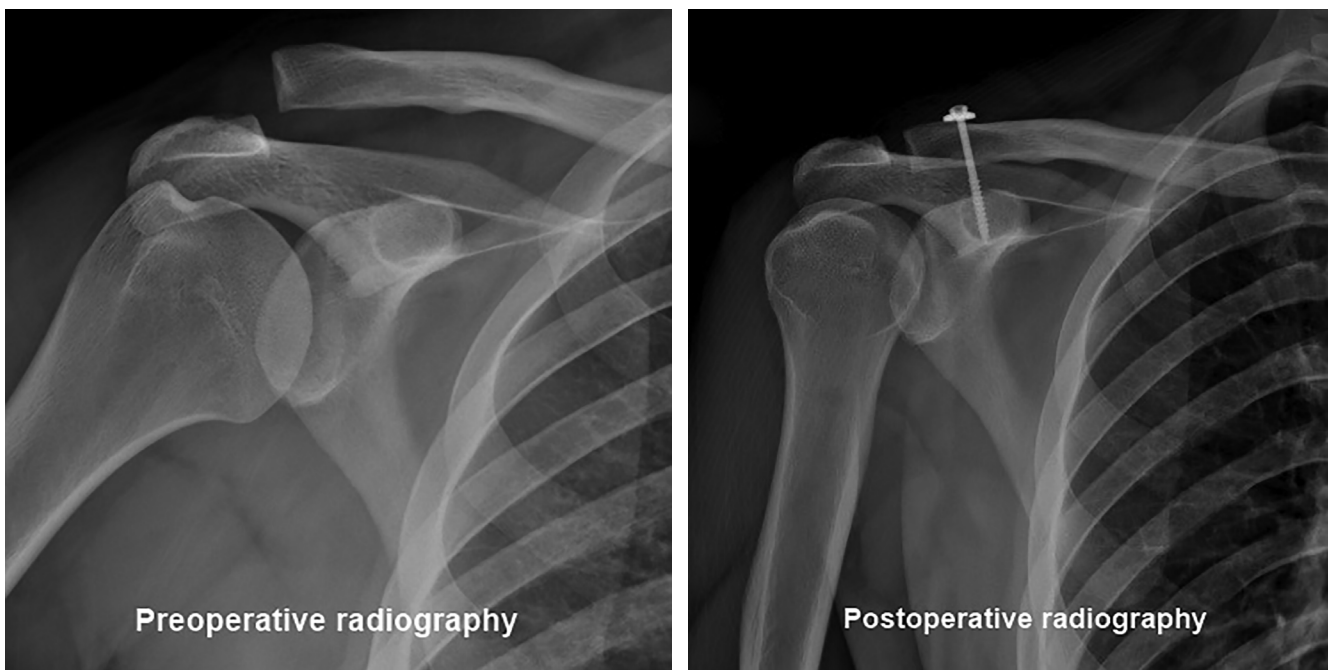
Bosworth technique radiography.
